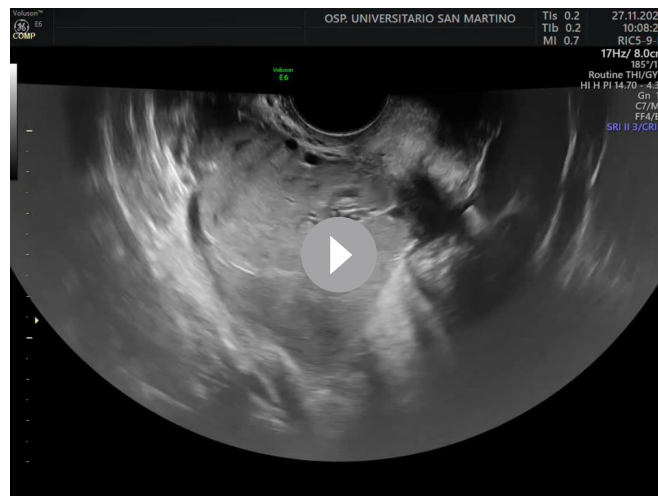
Transvaginal ultrasound showing (A) a hypoechoic irregular solid mass ($71 \times 60 \times 60$ mm) rising from the right lateral wall of the whole myometrium. (B) Power Doppler showing abundant vascularisation of the mass (colour score 4).
